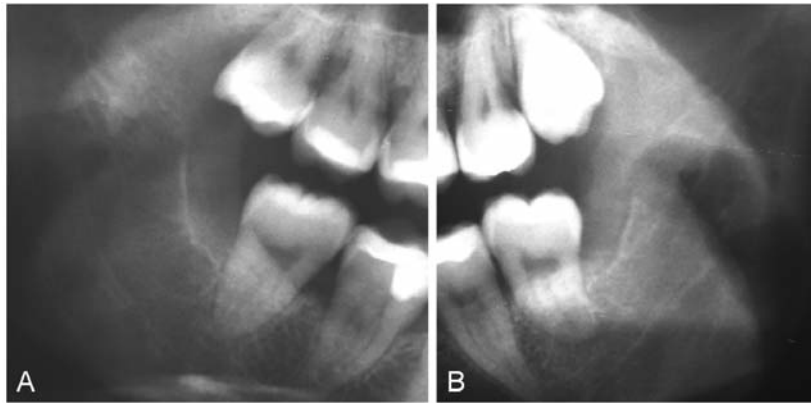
Postoperative orthopantomogram, 2 years after surgery: (A) right side, (B) left side. The lesions are completely ossified.
